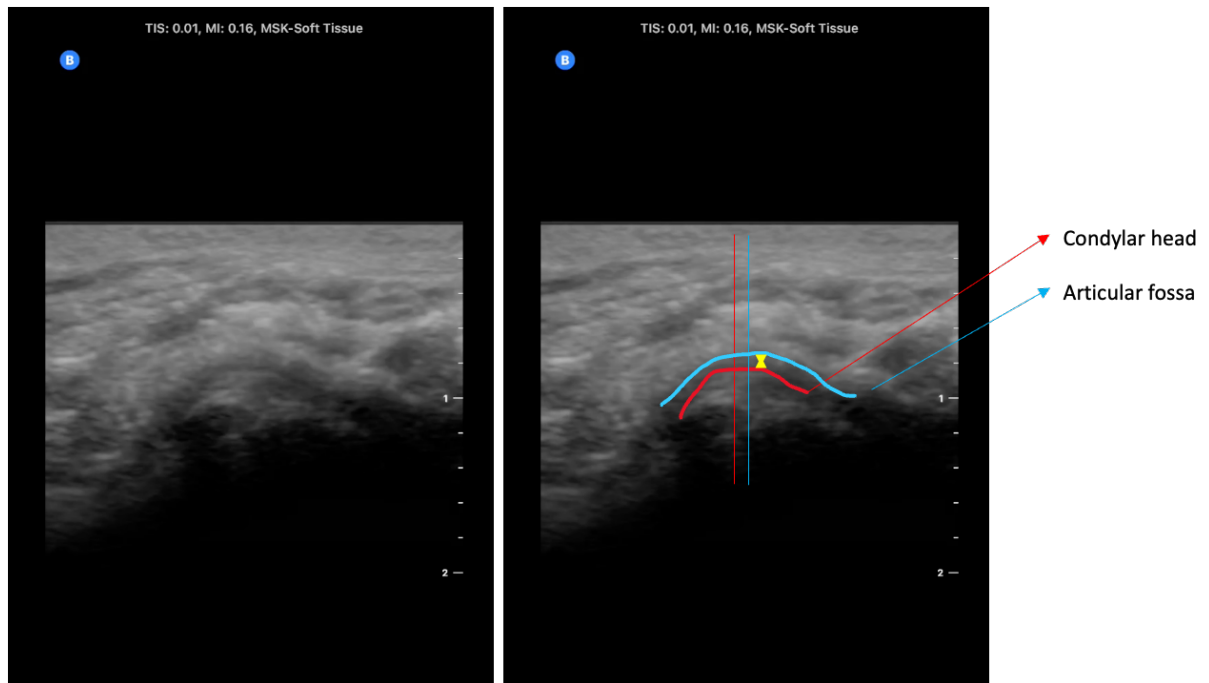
Ultrasound imaging of TMJ. Ultrasound imaging of the opposite joint in the same patient in Figure 5.2.1, in a closed mouth position. Note the decreased joint space and eccentric positioning of the condylar head within the glenoid fossa in a patient with ADDwR. Note that the red line corresponds to the centre of the condylar head and the blue line corresponds to the centre of the glenoid fossa, demonstrating that the condylar head is more posteriorly positioned. The yellow arrows indicate joint space.
